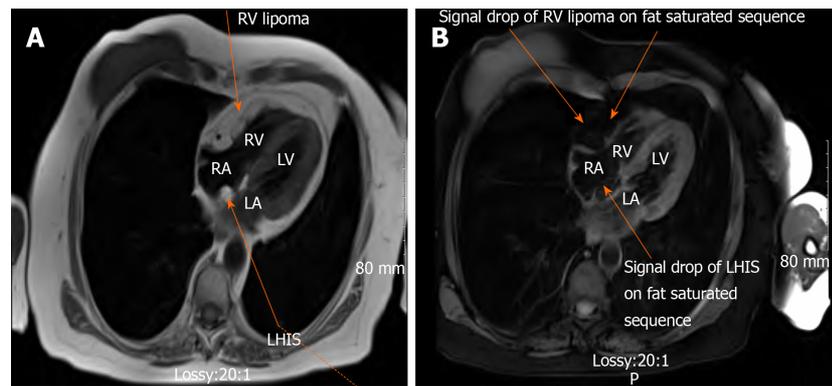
Cardiac magnetic resonance imaging. A: Axial section T1 weighted imaging showing (a) well-defined capsular homogenous mass along the epicardial surface of right ventricular, diffusely infiltrating the myocardium without frank invasion of adjacent structures (b) lipomatous hypertrophy of interatrial septum; B: Axial section T1 weighted imaging showing signal drop on fat saturated sequence of cardiac lipoma in right ventricular. RV: Right ventricular; LHIS: Lipomatous hypertrophy of interatrial septum.
